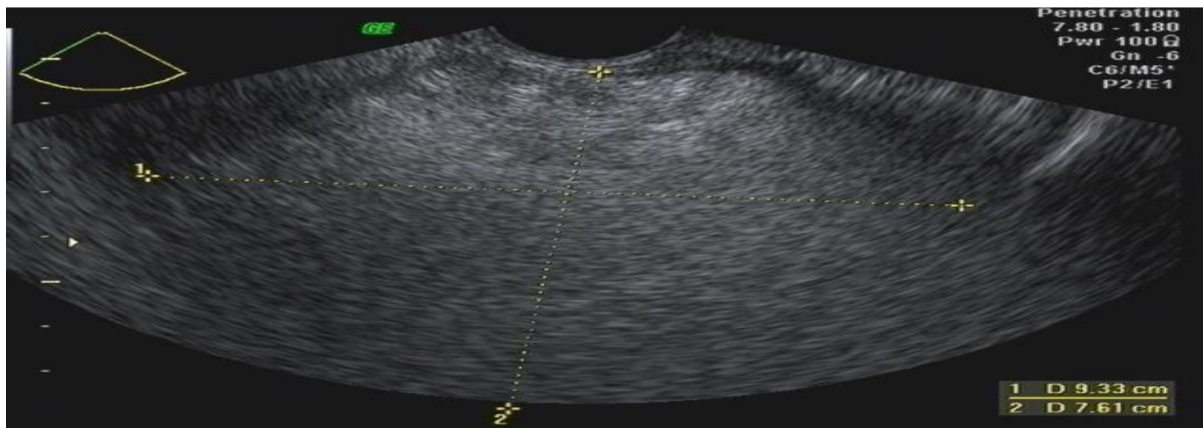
Transvaginal ultrasound in a 70-year-old woman.
